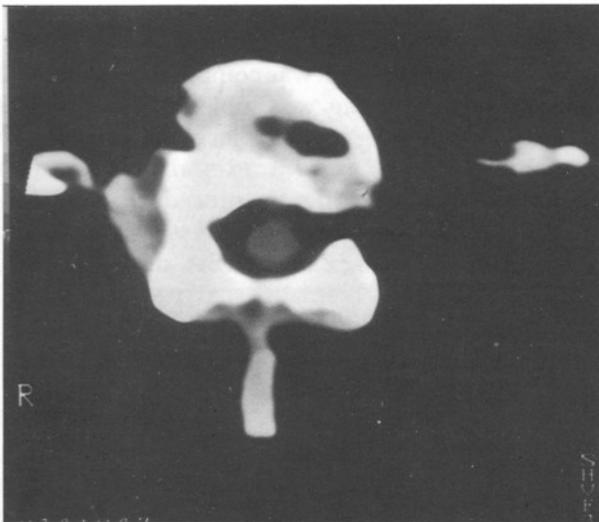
After 15 W, 1 s, 75+25 pulses(1,500 joules) of LN: A) 1/3 of the disc was seen to be vaporized on CT scans, B) but the best MR frame was not sufficient to make this determination.
